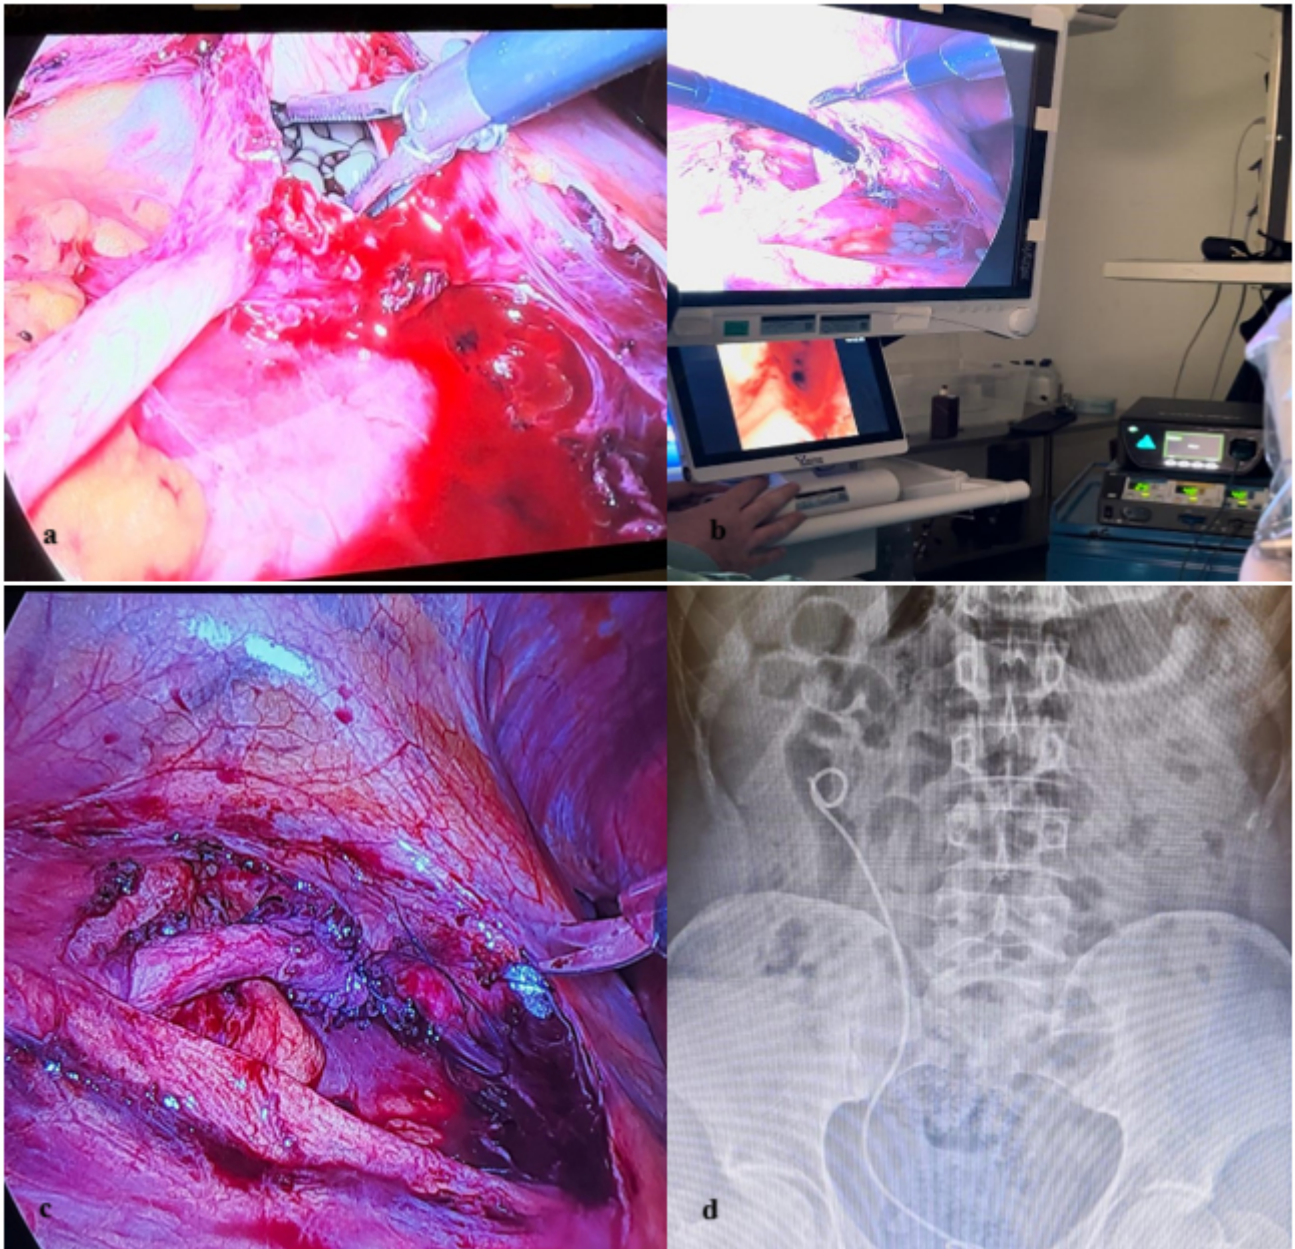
Surgical procedure steps and postoperative KUB radiography. (a) Opening the renal pelvis and removing the stones with forceps. (b) Access with flexible cystoscopy for residual stones. (c) Anastomosis after dismembered pyeloplasty. (d) Control KUB radiography.
